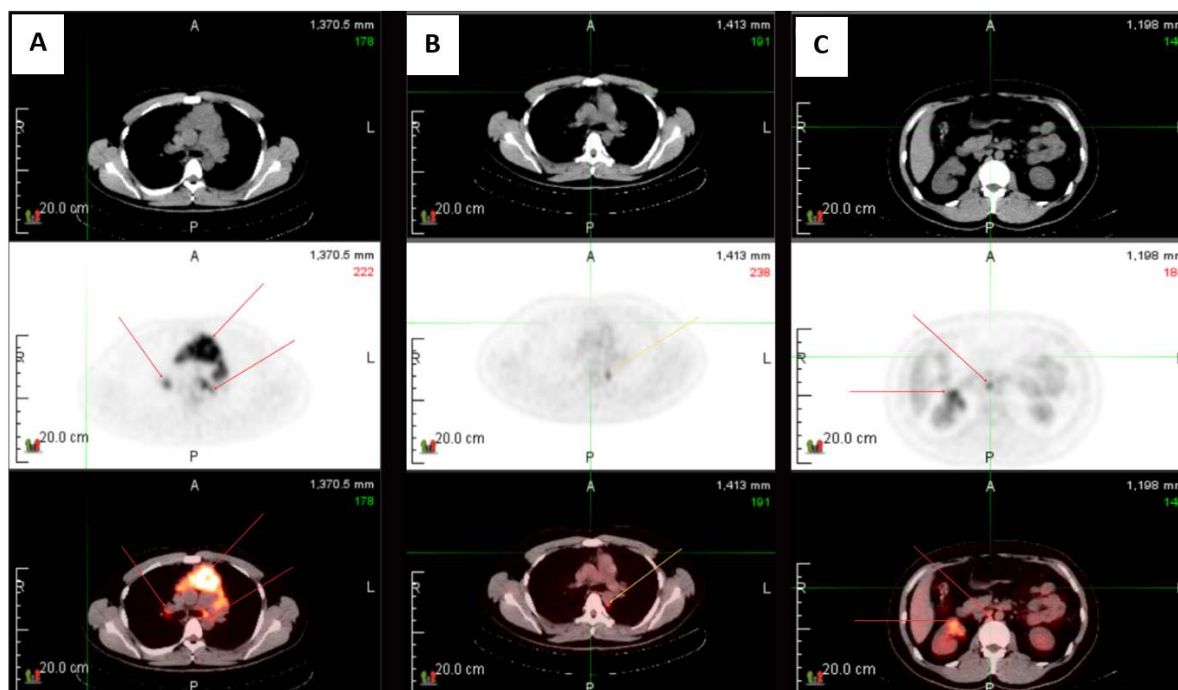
Axial CT (top), PET (middle), and fused PET/CT images (bottom): (A) 10 July 2020 PET image showed increased FDG uptake in the paratracheal, paraesophageal, and paracardial region (red arrow). (B) 18 January 2021 After completing chemotherapy, it showed a significant but incomplete response with some residual disease and a new nodal focus localized in the paravertebral region at the T-V level (SUV: 6.51) (yellow arrow). (C) 18 January 2021, a new intense focus of FDG avidity (SUV: 7.32) in the aortocaval region at the L-II level (red arrow) and a new irregular nodule ($\pm 1 \times 2$ cm) in the inferior pole of the right kidney (red arrow), suggestive of the metastatic process.
